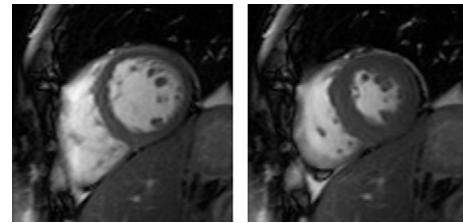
Cardiac MR images at end diastole (left) and end systole (right).
